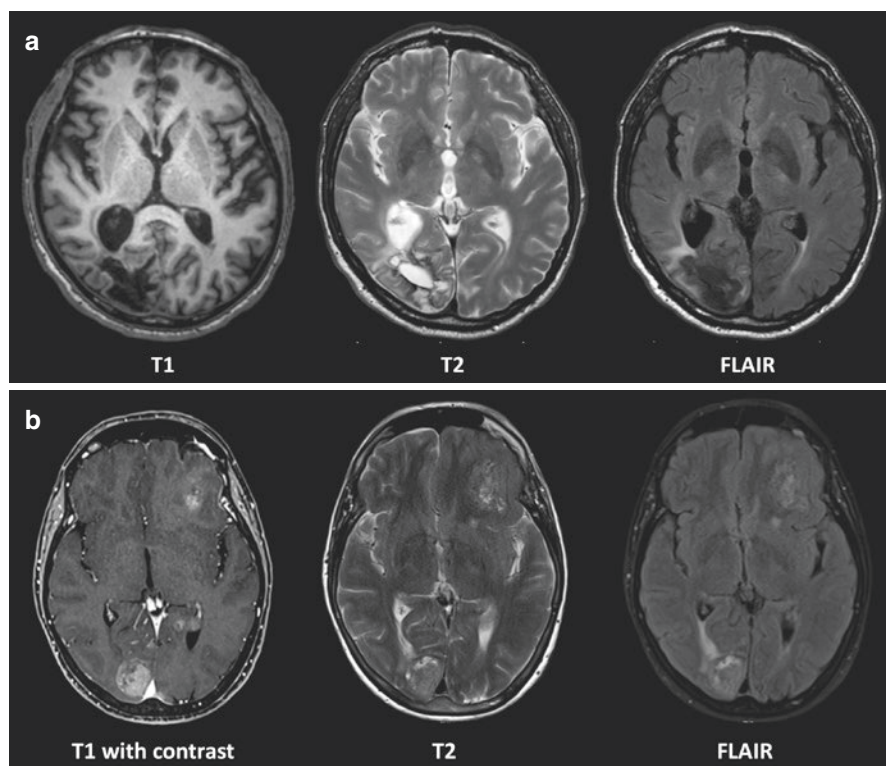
Two cases of Charles Bonnet syndrome. Patient (a): male, 65 years old. He presented a hemorrhagic stroke in right occipital lobe with residual left hemianopsia. After 6 months, he went to the emergency room for acute visual hallucinations in left visual hemifield: colored pillow on the table, black worms on the wall, water puddles on the floor, and soccer players on the front of a building. Brain MRI showed a malacic area related to the old stroke (T1-weighted, T2-weighted, and FLAIR scans). EEG was negative. Hallucinations suddenly disappeared with valproate therapy. Patient (b): female, 62 years. She went to the outpatient department for headache lasting 2 weeks and visual hallucinations in left visual hemifield, with tigers and lions. Brain MRI showed multiple metastasis from mammalian cancer (gadolinium-enhanced T1-weighted, T2-weighted, and FLAIR scans). EEG was negative. Hallucinations appeared in the left visual hemifield, due to hemianopsia related to right occipital lobe lesion
